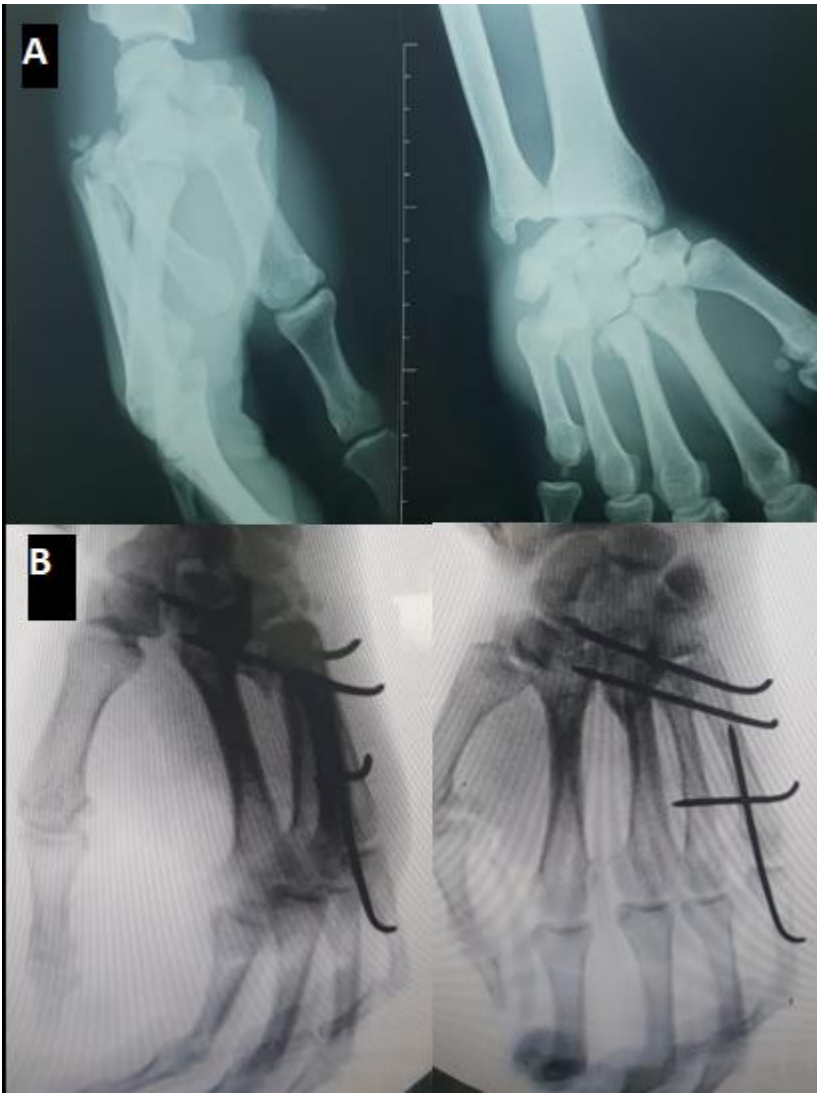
(A) hand X-rays showing a floating fifth metacarpal; (B) fluoroscopic control showing percutaneous Kirschner wires fixation
